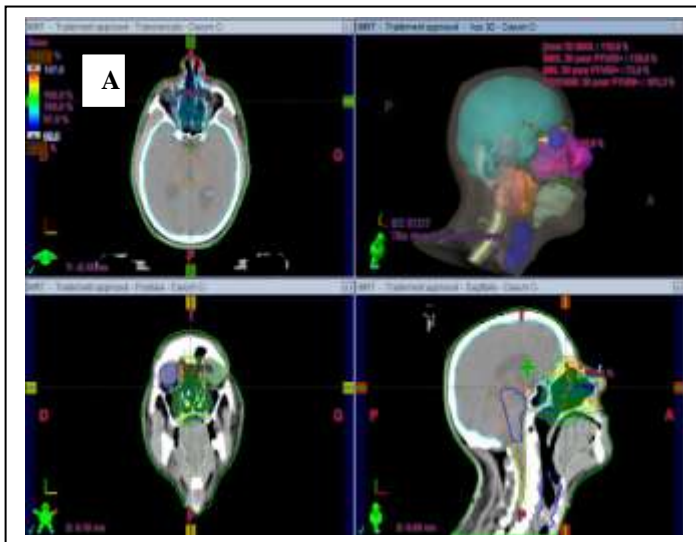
Series of axial, sagittal, and coronal scans from the dosimetric CT depict the distribution of the dosage within the PTV (marked in blue) (A), alongside the configuration of beams across the three planes (axial, coronal, and sagittal) (B)
